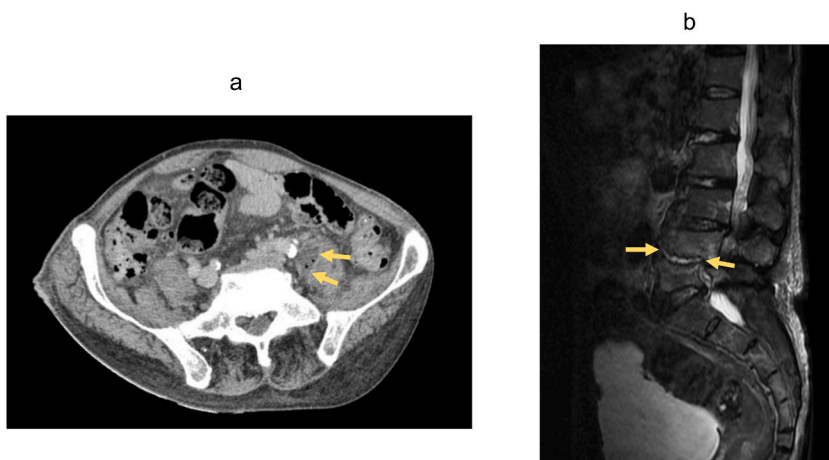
(a) Abdominal computed tomography showed a low-density area of left-sided iliopsoas muscle swelling (yellow arrow). (b) Short tau inversion recovery magnetic resonance imaging depicted enlarged high-signal areas in the L4/5 intervertebral disc (yellow arrow) and in the upper and lower vertebral bodies.
